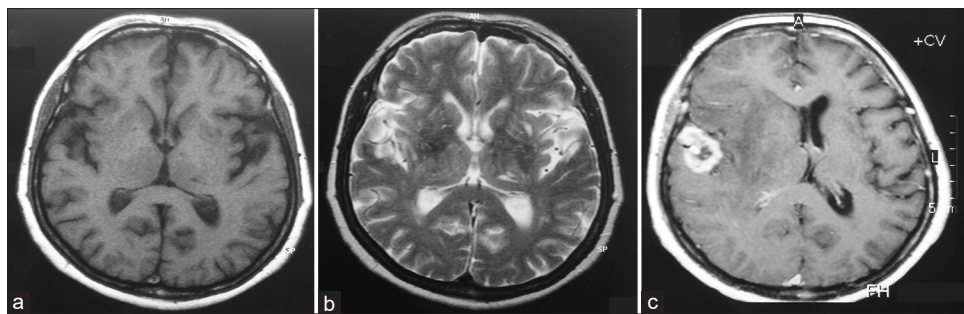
Case 2. Initial noncontrast axial T1-weighted (a) and T2-weighted magnetic resonance imaging (b) with no abnormality. A well-demarcated mass lesion in the right temporal lobe showing strong contrast enhancement on T1-weighted magnetic resonance imaging (c) 3.5 months later; the sulci were closed and midline structures were swollen because of edema in the right cerebral hemisphere
